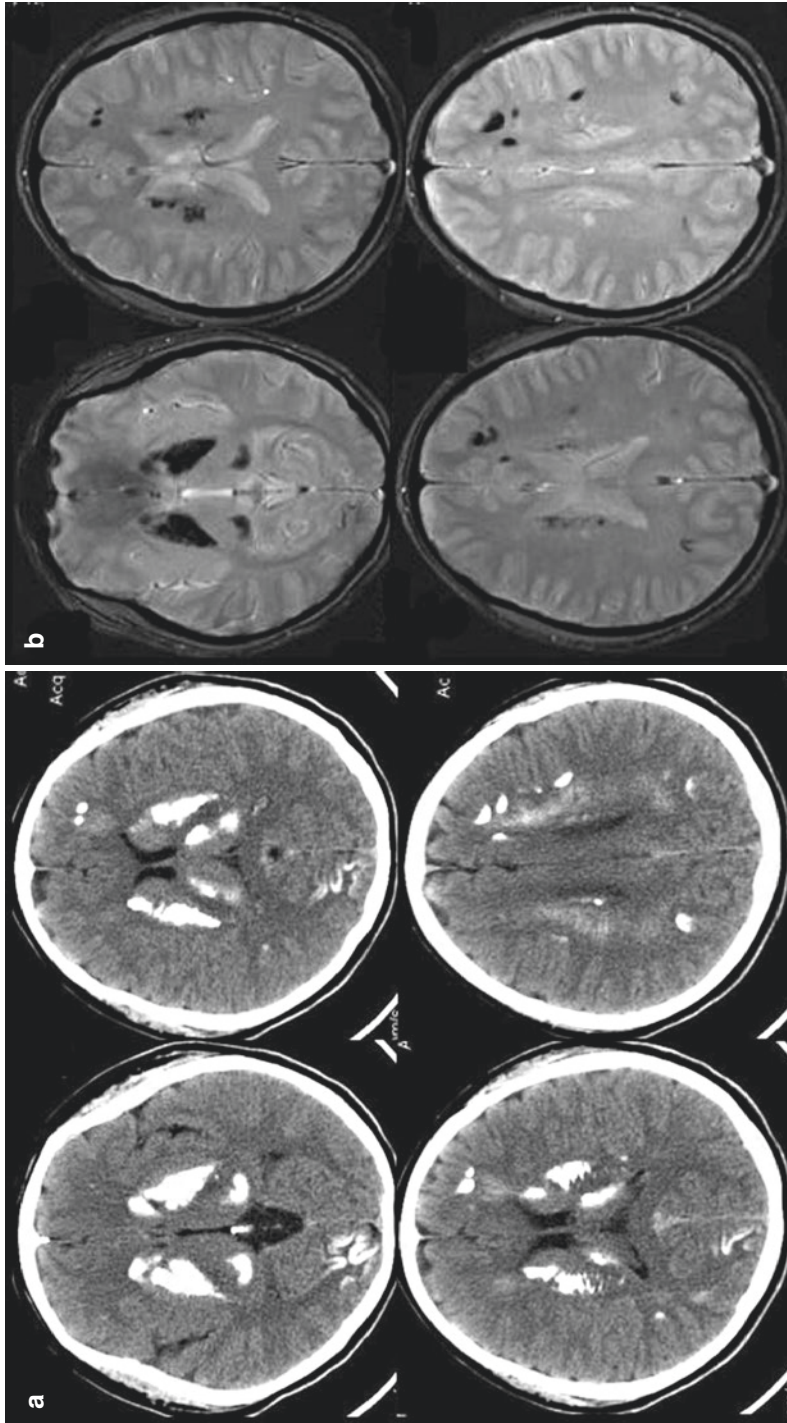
(a, b) MRI and CT of the brain in a patient with mixed PKD and PNKD in pseudohypoparathyroidism (Video and image courtesy: Anthony Lang, MD). Head CT shows calcification, and brain MRI is suggestive of mineral deposition
